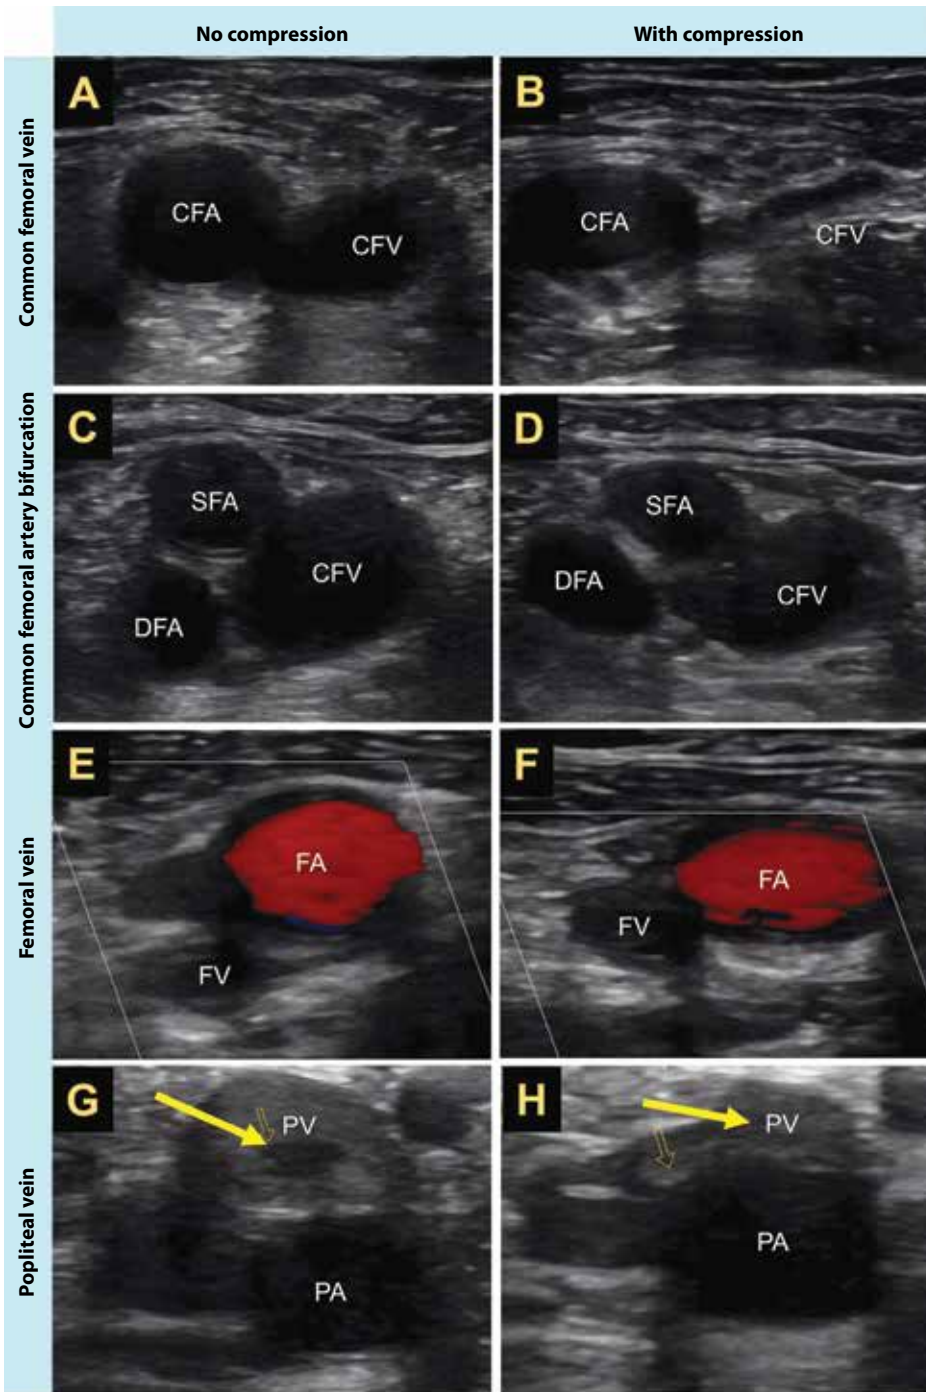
Point-of-care ultrasound images of right-leg deep veins and arteries viewed in transverse, without and with compression. Large yellow arrows denote possible thrombi that can be visualized. A, B: Proximal common femoral vein (CFV) and proximal common femoral artery (CFA). C, D: Distal CFV, and bifurcation of the CFA into superficial femoral artery (SFA) and deep femoral artery (DFA). E, F: Femoral vein (FV) and femoral artery (FA). G, H: Popliteal vein (PV) and popliteal artery (PA). Note the noncompressible distal CFV extending down to the PV, with the appearance of a possible thrombi in the PV.
